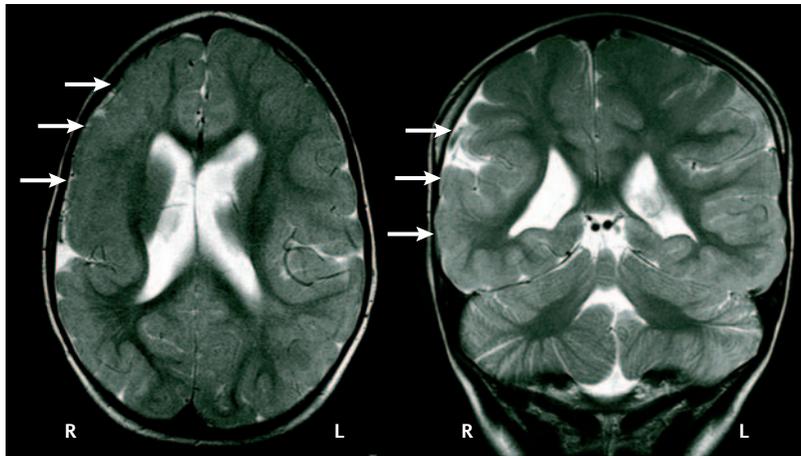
Unilateral polymicrogyria detected using MRI. Polymicrogyria (indicated by arrows) is detectable in the right hemispheres in both brains shown. An apparent increase in cortical thickness is observed in the right (R) hemispheres, whereas the cortices of the left (L) hemispheres appear entirely normal. Modified, with permission, from REF. 92 © (2006) Lippincott Williams & Wilkins.
